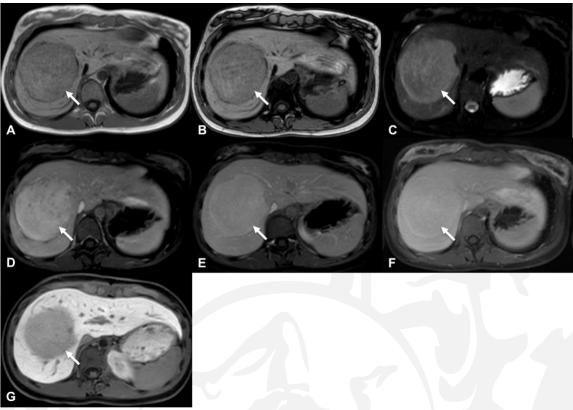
35-year-old woman with inflammatory HCA (white arrow). MRI. In-phase (A) and opposed-phase (B) T1-weighted gradient-echo sequence showing moderate-low intensity without any signal drop on opposed phase. (C) On respiratory-triggered fat-suppressed turbo spin-echo T2-weighted imaging, the lesion is hyperintense compared to the surrounding liver. 3D fat-suppressed gradient-echo T1-weighted acquisitions after intravenous injection of gadolinium chelate (gadoxetic acid): the lesion shows a strong homogenous enhancement on arterial phase imaging (D), with persistent enhancement on portal venous (E) and delayed phases (F). On hepatobiliary phase (G), the lesion is hypointense.
